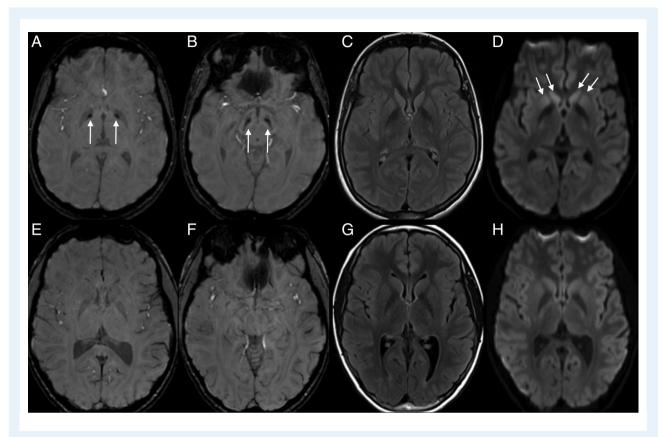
Axial SWI (A,B,E,F), FLAIR (C,G), and diffusion trace (D,H) sequences for the VAC14 proband at 14 years of age (A–D) and an age-/sex-matched control evaluated for headache (E–H). SWI imaging demonstrates abnormal susceptibility in the globus pallidus internus (arrows, A) and SN (arrows, B) as well as subtle diffusion abnormality in the corpus striatum (arrows, D). There was no convincing T₂/FLAIR hyperintensity in the basal ganglia or SN (C). FLAIR, fluid-attenuated inversion recovery; SWI, susceptibility-weighted imaging.
